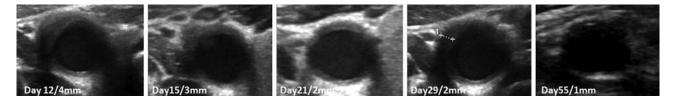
Follow-up examinations. Sonographic serial follow-up imaging showed that wall broadening halved after 15 days and appeared to be normal in the last sonographic control after 55 days
